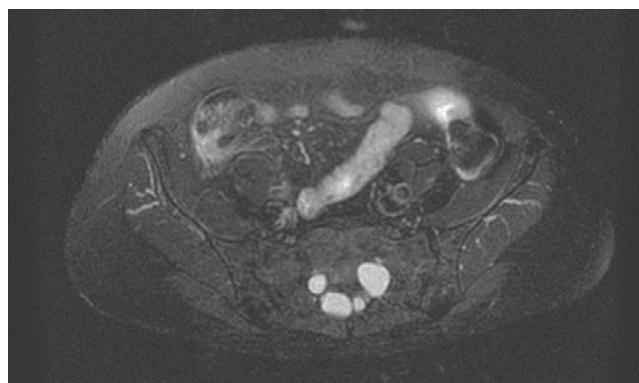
An axial fat-suppressed T2-weighted image shows multiple Tarlov cysts in the sacrum. Tarlov cysts are extradural CSF-filled sacs that occur in the S1-S4 region of the spine and are often asymptomatic.
